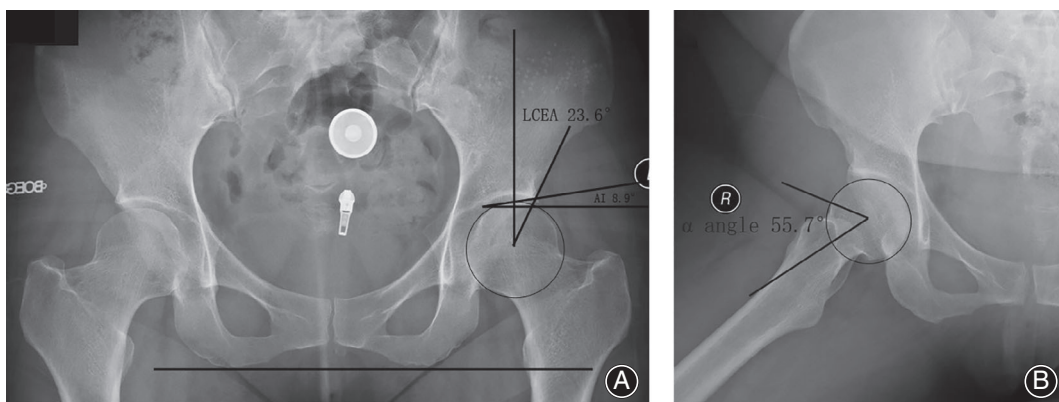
(A) The radiographs used the anteroposterior views of the pelvis to assess lateral center-edge angle (LCEA) and acetabular inclination (AI); (B) The radiographs used the frog-leg lateral views of the hip to assess the α angle.
